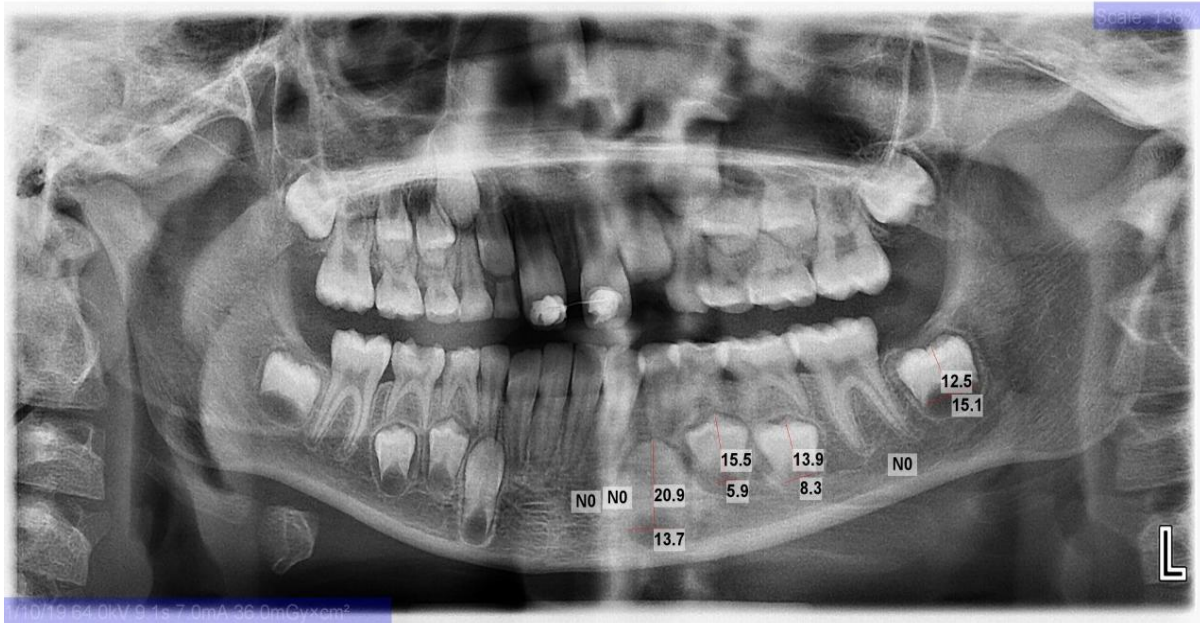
An example of measurements for Cameriere formula on a sample of panoramic radiographs.
